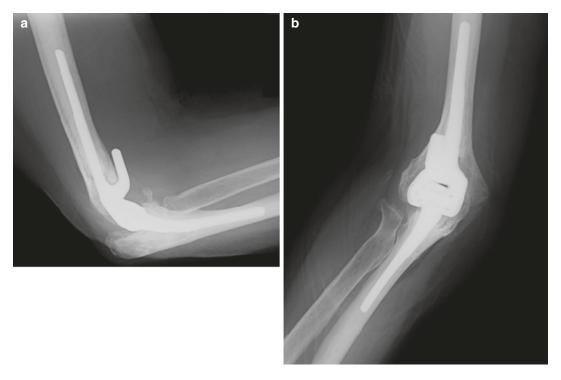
X-rays obtained at 1-year follow-up: (a) lateral view and (b) oblique view from total elbow arthroplasty with a Coonrad-Morrey type III implant
